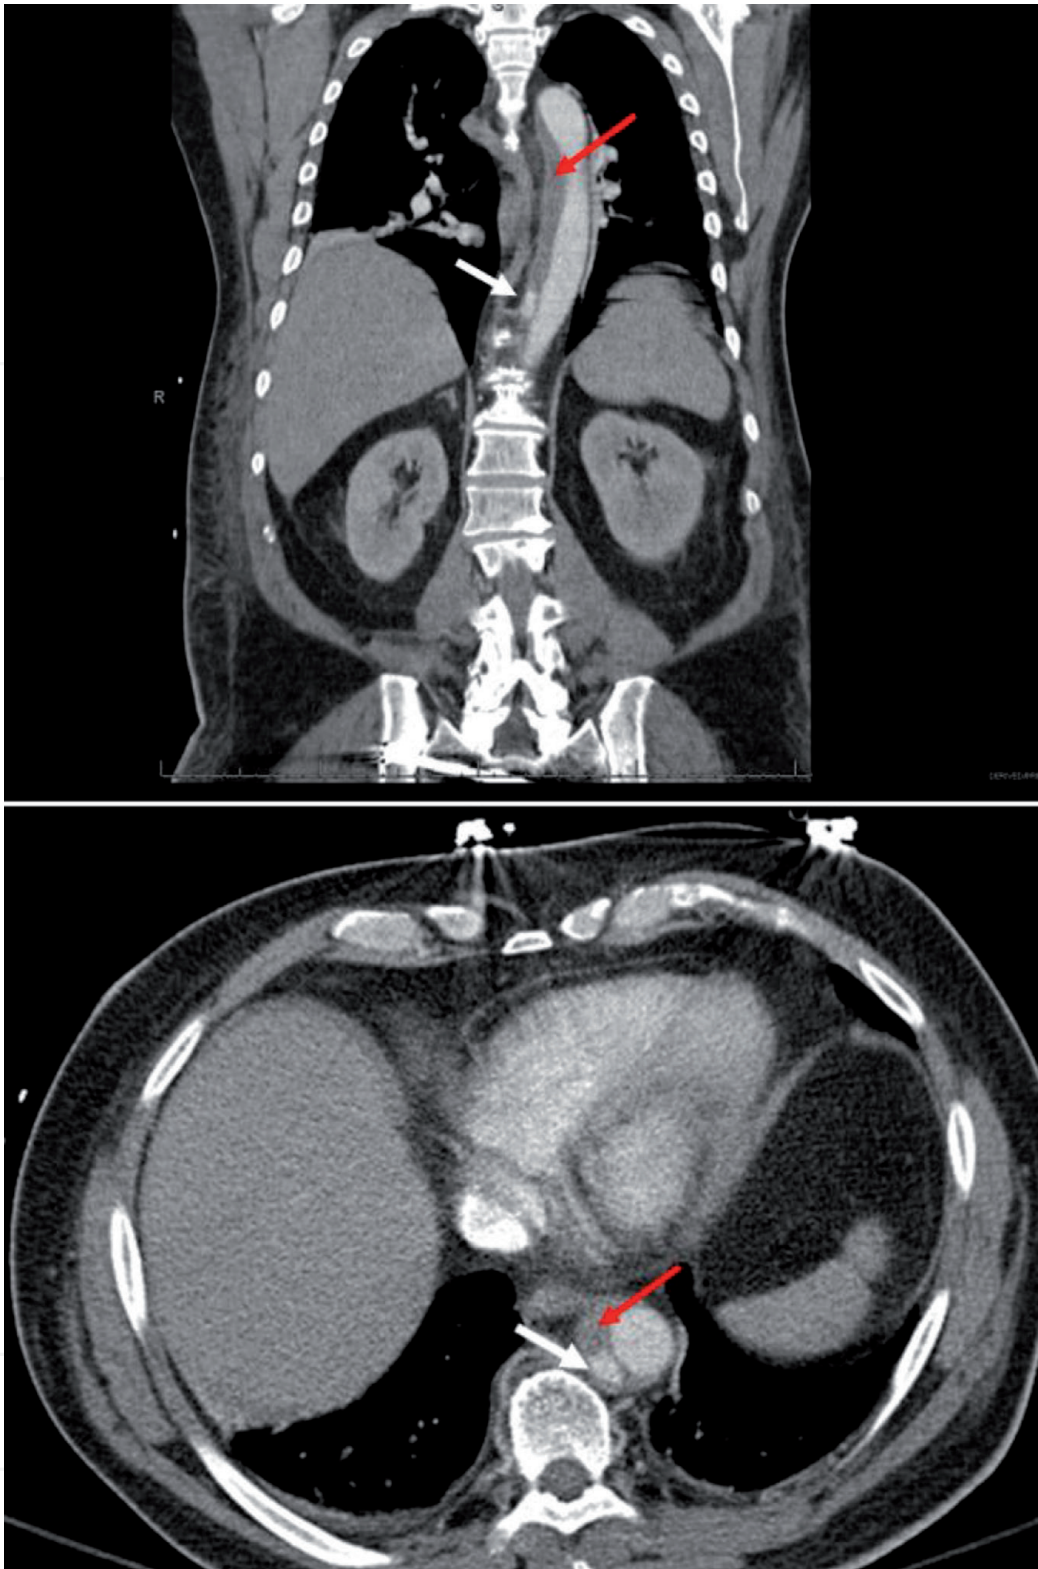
CT scan of the chest with IV contrast demonstrating aortic transection near the isthmus (red arrow), also associated with intraluminal aortic thrombus as shown by the blue arrow. (transection is defined by total or partial interruption of the column of intra-venous contrast flowing within the aortic lumen).
